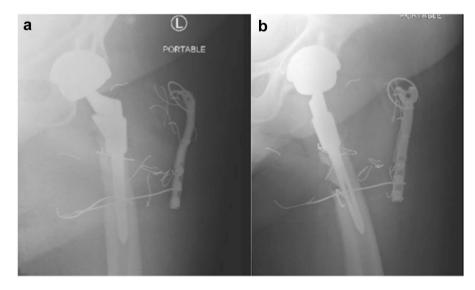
(a) Preoperative anteroposterior radiograph of the left hip demonstrating hardware failure with migration. (b) Preoperative lateral radiograph of the left hip left hip radiograph demonstrating hardware failure with migration.
